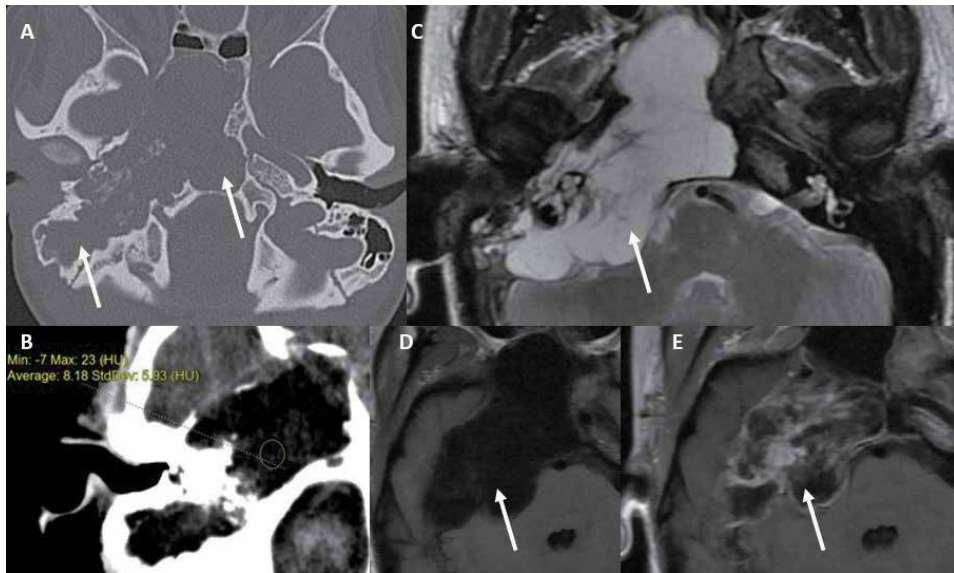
Chondromyxoid fibroma: Bone window (A) and soft tissue window (B) axial CT head images show a well-defined lobulated lytic lesion (white arrows) involving the mastoid and petrous parts of the right temporal bone and clivus. A note is made of the low attenuation value of the CMF lesion and absent calcifications. On the T2-weighted image (C), the CMF lesion demonstrates a peripheral hypointense sclerotic rim with an intrinsic high signal (white arrow). It shows a hypointense T1 signal (D) and shows thick peripheral enhancement (E). MR features to support the diagnosis of the chondromyxoid fibroma (CMF).
